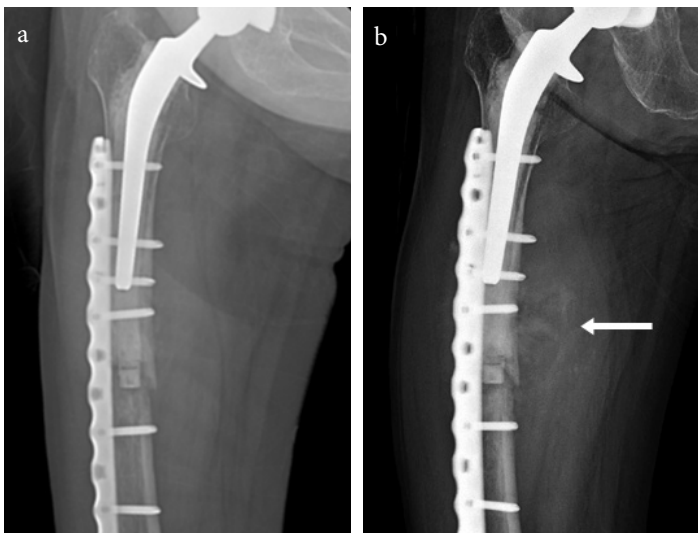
a, b. Radiopaque shadow on AP radiograph 2 months postoperatively (a) and 4 months postoperatively (arrow indicates multiple radiopaque mass-like lesions) (b)
